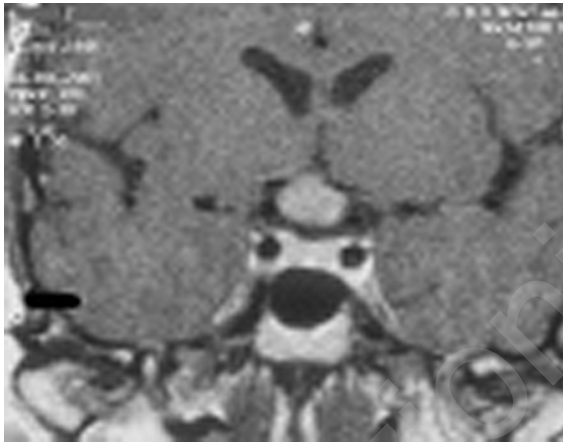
Coronal contrast-enhanced T1-weighted MR image shows optic chiasm infiltration 1.7 x 1.3 cm. Pituitary gland is normal.
